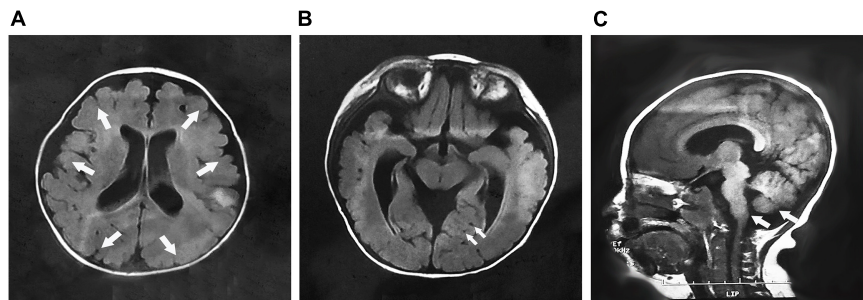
The brain MRI of patient 10 at 7 months of age. (A) Cross-sectional imaging showed polymicrogyria in the frontal, temporal, parietal, and occipital regions (arrows); (B) multiple cysts were identified in the cerebellum (arrows); and (C) sagittal imaging showed the cerebellum and brainstem dysplasia (arrows).
